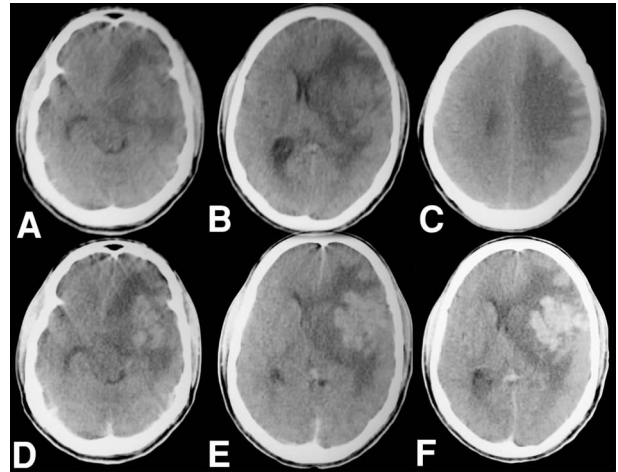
CT scans plain showing an isodense lesion in left fronto-temporal lobe showing coalescing nodular enhancement with peri-lesional oedema, mass effect and midline shift suspected as high grade glioma
